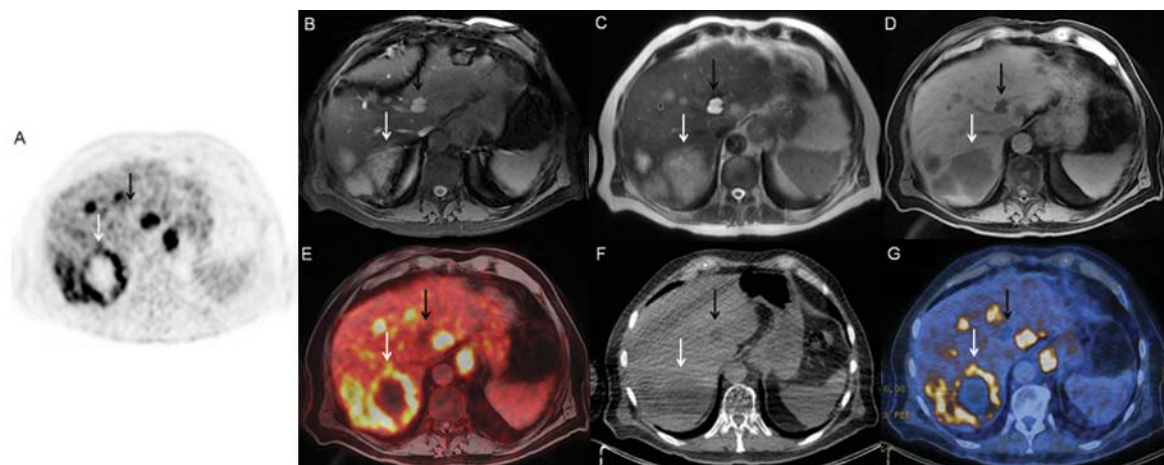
Comparison of PET/CT and PET/MR imaging in a patient with diffuse liver metastases of stomach cancer. Axial PET image shows metabolically active liver lesions (white arrow) in ¹⁸F-FDG-PET (A). The corresponding MR images with FIESTA (B) and SSFSE (C) sequence showing an inhomogeneous hyperintense signal in the center of the liver lesion indicating a necrotic zone. LAVA sequence (D) shows a homogeneous hypointense center of the lesion with a sharp demarcation against normal liver tissue (white arrow). Faint demarcation of these lesions on CT (F) (white arrows). PET/MRI (LAVA) (E) and PET/CT (G) showing elevated ¹⁸F-FDG uptake at the border (white arrow) of the lesions indicating viable tumor in the periphery. Note the non-avid liver lesion (black arrow, A-G) close to the middle hepatic vein in segment IVa (cyst).
